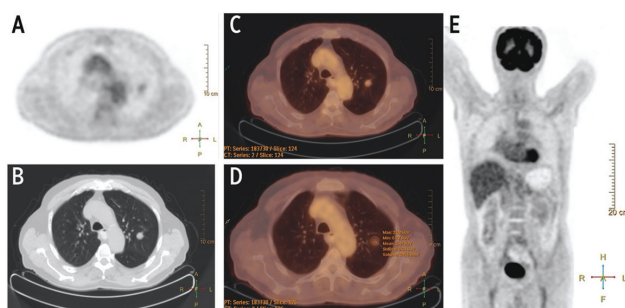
A well-defined and solid solitary pulmonary nodules was detected in left upper lobe in positron emission tomography (PET) image. (A) Axial non-contrast Thorax computed tomography (CT) at parenchyma window (B), and PET/CT image (C). Measurement of activity parameters were consistent with benign lesions on PET/CT image (D). MIP image of total body PET showed no significant activity (E)
